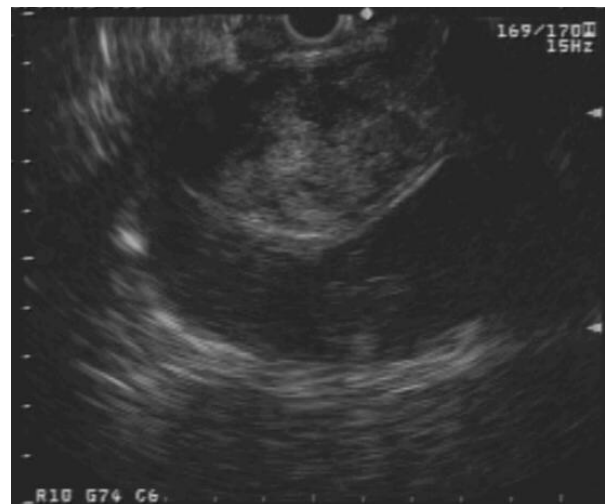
Linear array endosonographic image of a large cystic mass in the head of the pancreas with heterogeneous solid area.
